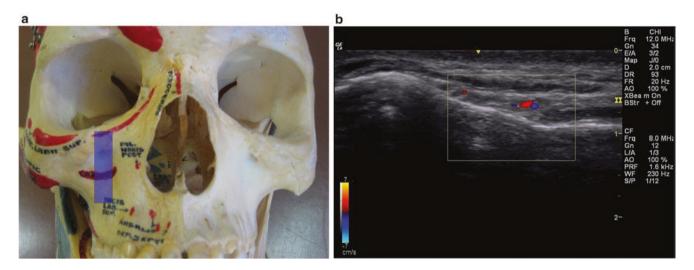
Scanning technique for infraorbital nerve injection (a) Sagittal position of the transducer (semitransparent color rectangle), (b) Doppler mode identifying vessel
